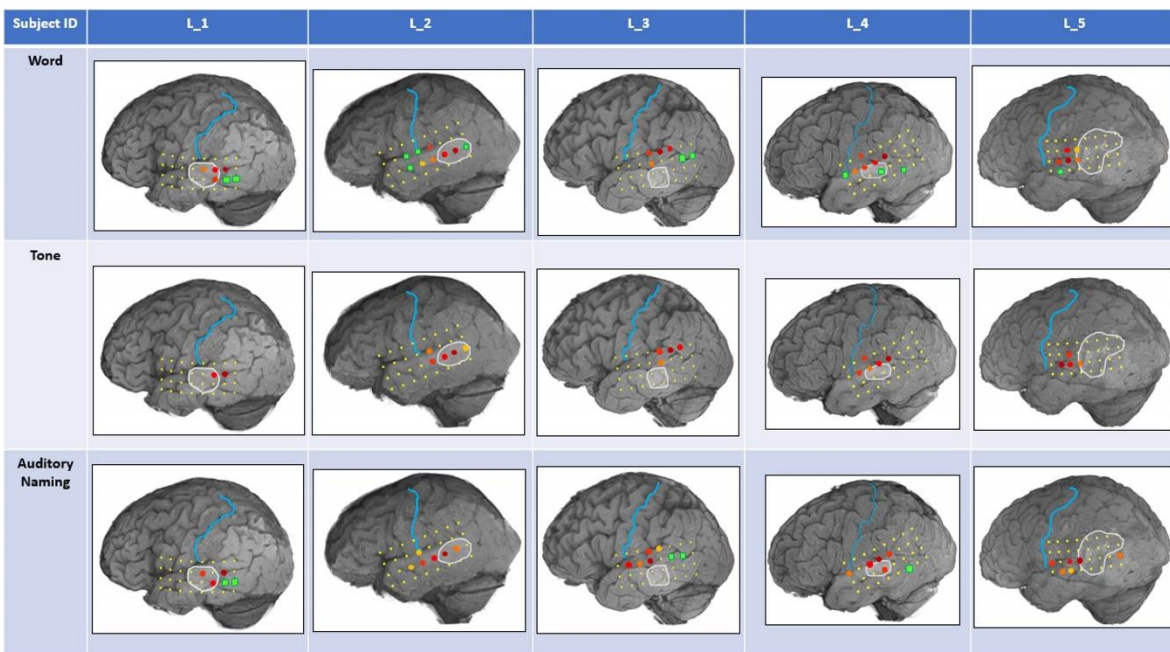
ECoG high-gamma band (50~300Hz) activation profile induced during different auditory processing tasks, across five subjects. 3D cortical brain mesh from patient-specific pre-operative MRI scans, tumor regions (grey curve) and central sulcus (cyan) are marked. Electrode contacts (small yellow dots), task-specific high-gamma modulated contacts (larger circles; signal propagation denoted by color gradient: from red to orange) and late activated contacts (green squares) are also marked.
